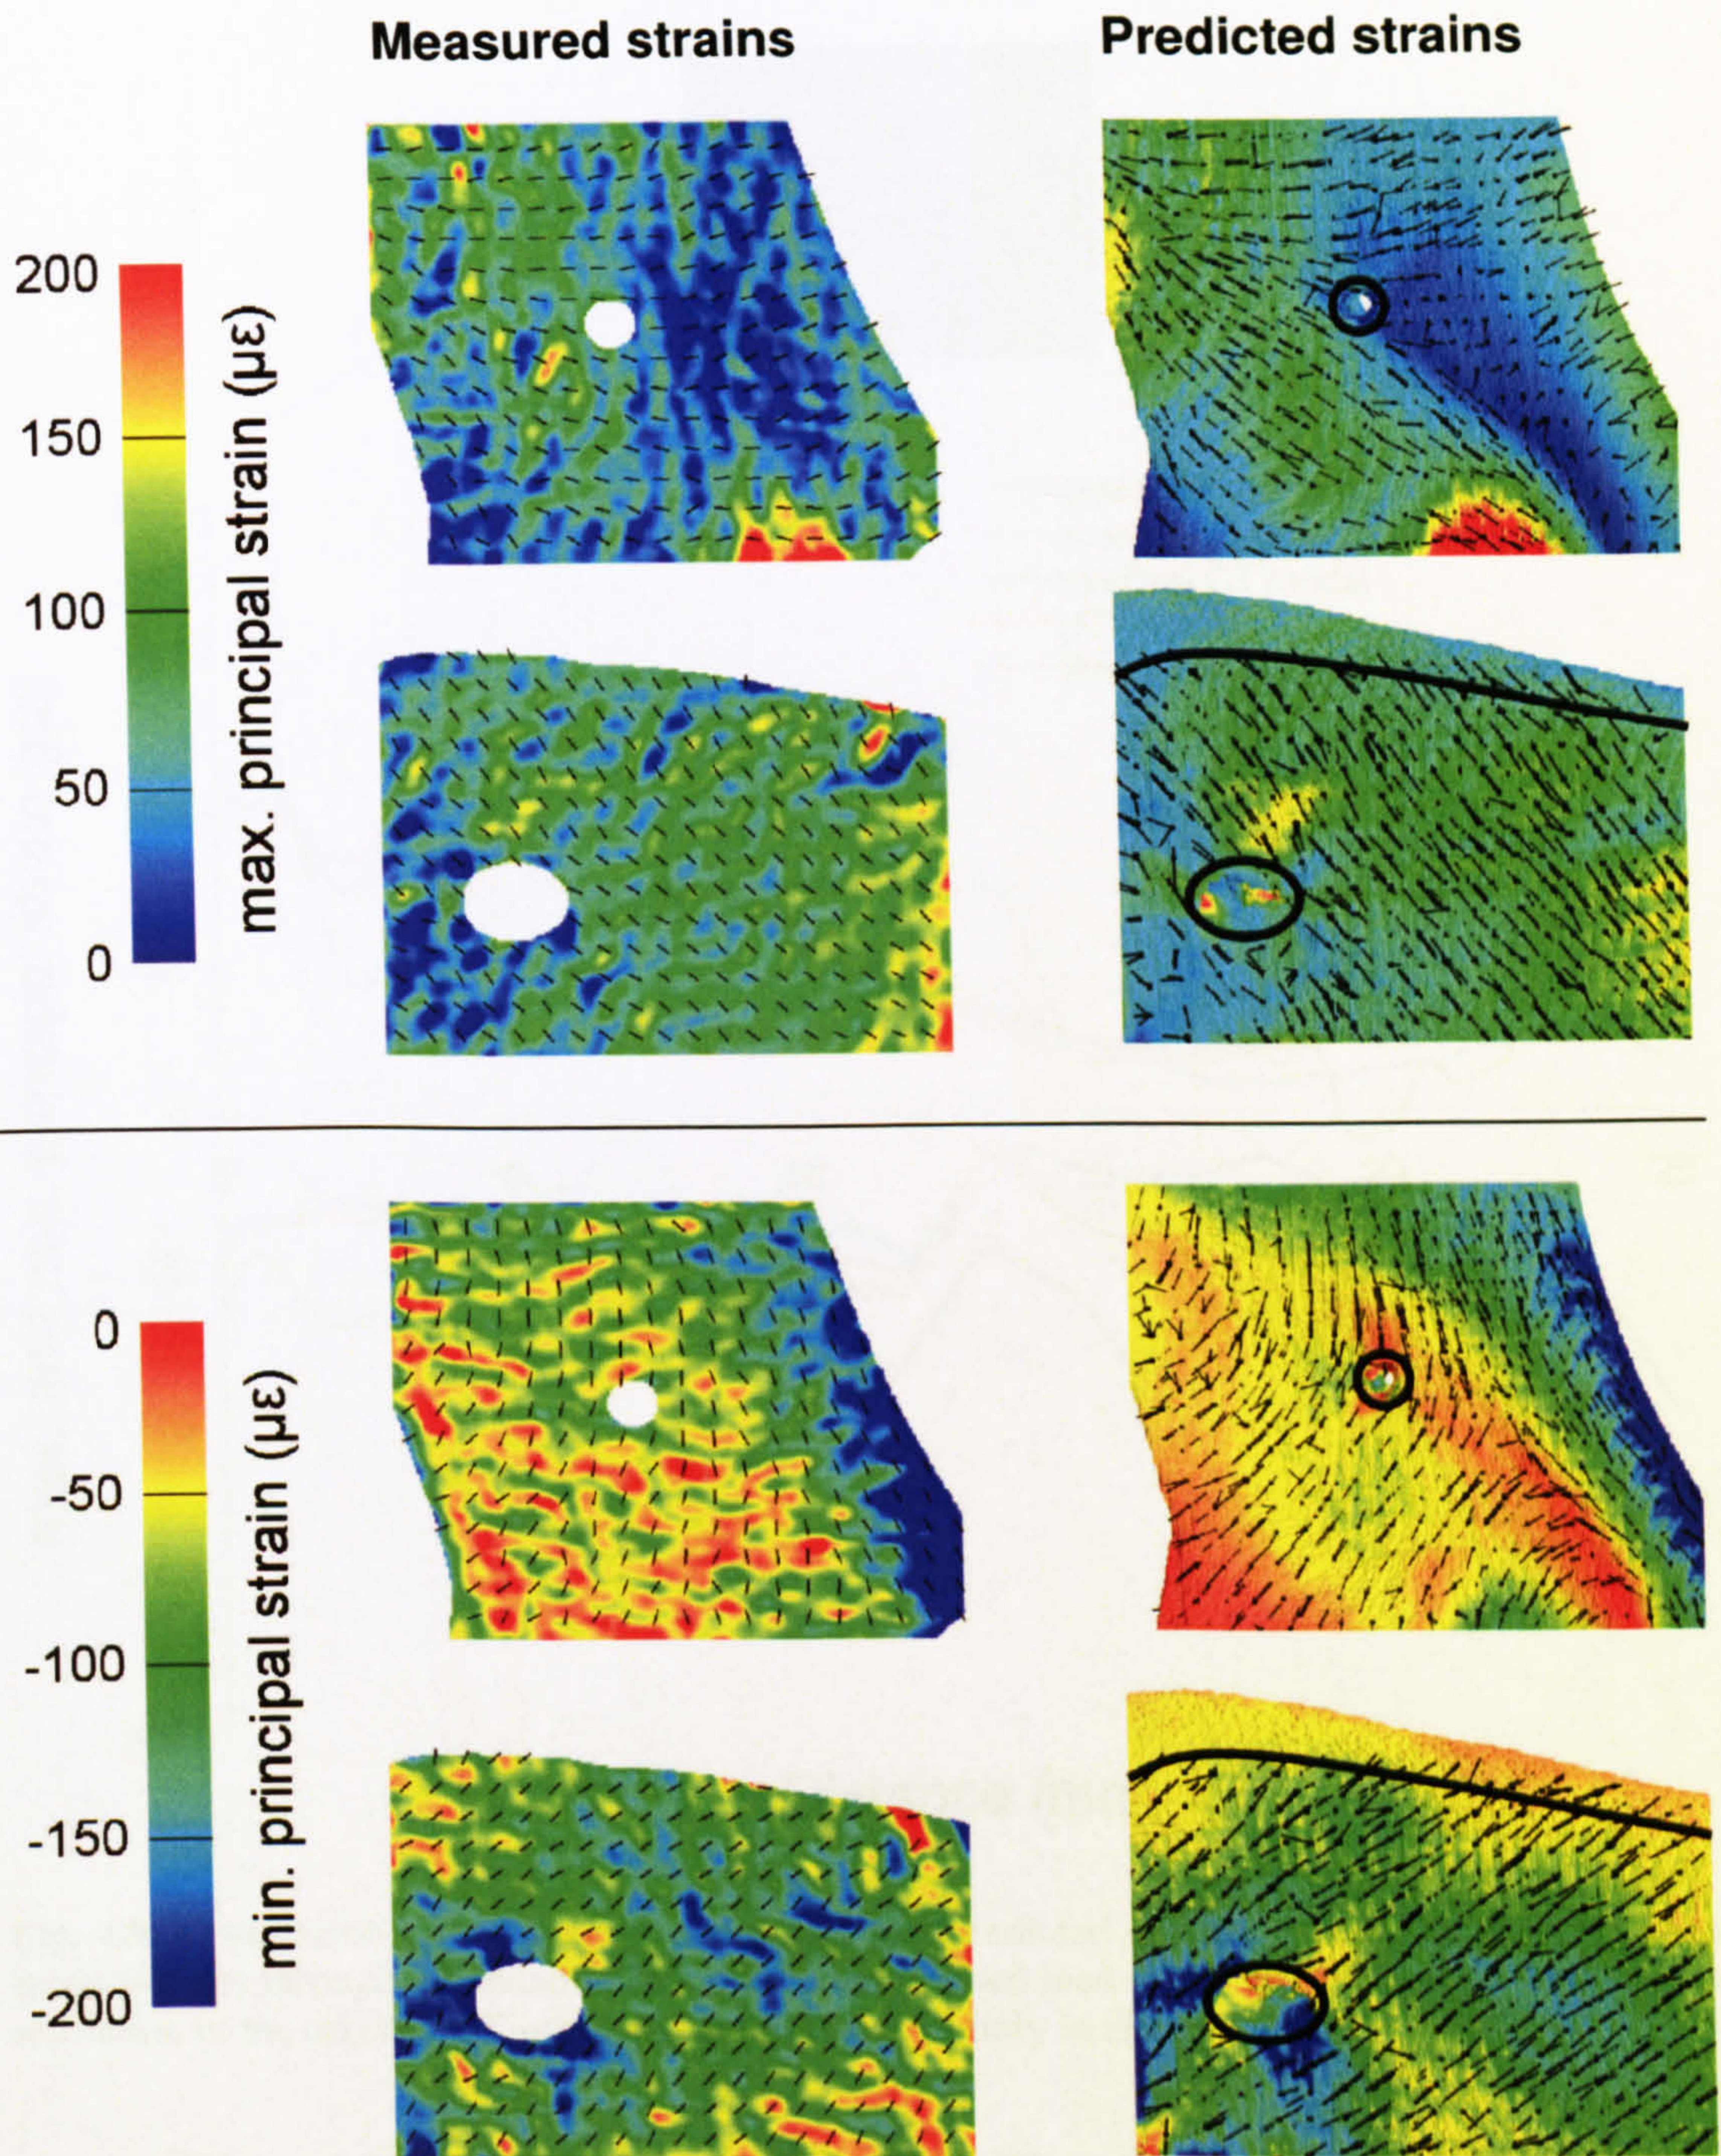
Comparison of predicted and measured minimum principal strains in the two measurement areas for an applied load of 250 N. The FE model shown is the high-resolution μ CT model (element size = 0.135 mm). Top and third rows: measurement area on the mandibular ramus; second and bottom rows: measurement area on the mandibular corpus. The black lines indicate the strain directions.
